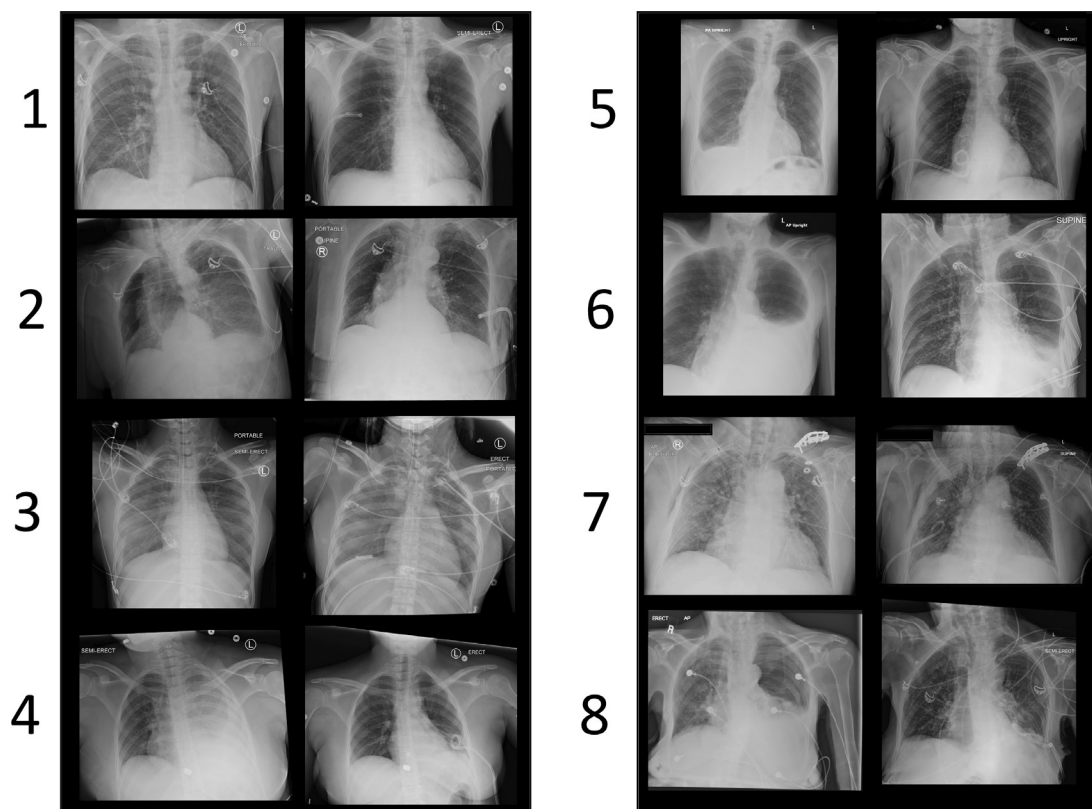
Chest X-rays before and after each reported thoracostomy excluding the detailed example.
